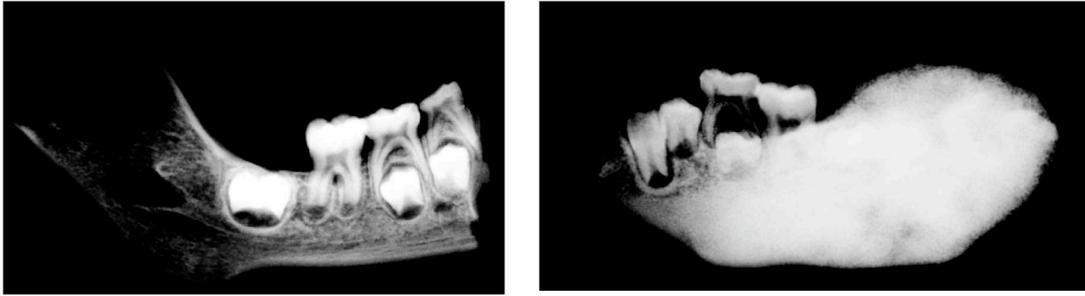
Radiographs of mandible from Skeleton 177. Right portion is normal, however left portion shows radio-dense expansive lesion and ‘orange peel’ appearance. Image D Thompson/ G Craig.
